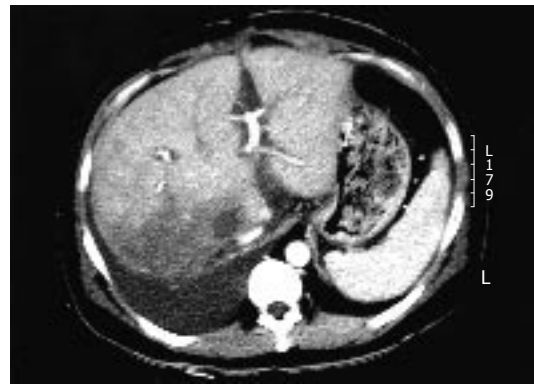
Computed tomography scan showing atrophy of the right posterior segment of the liver graft.
